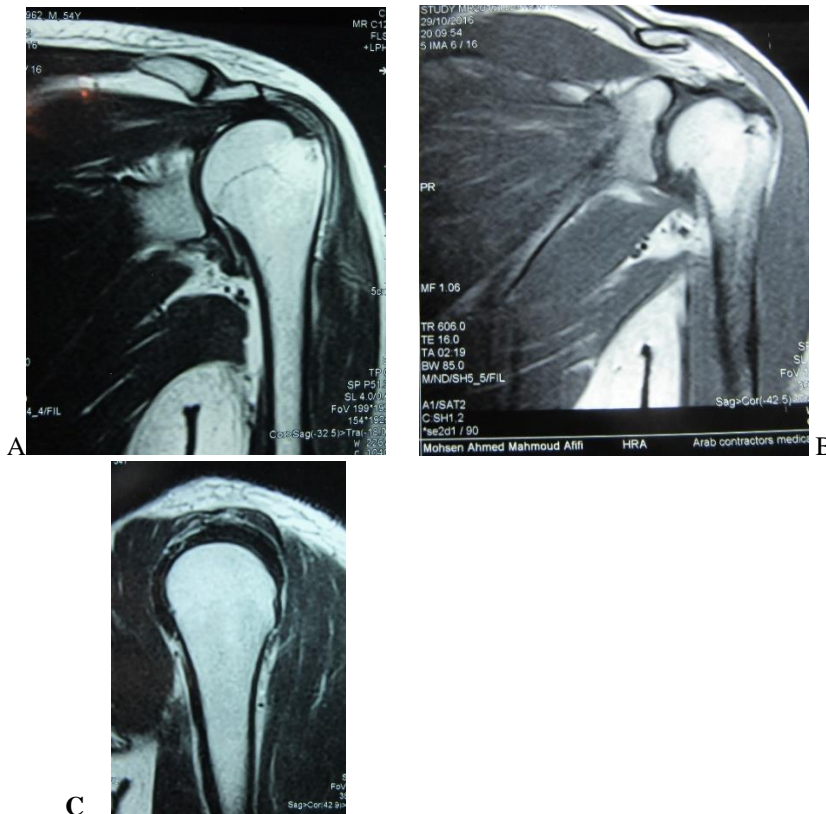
showing the post-operative MRI coronal and axial views with good tendon healing
